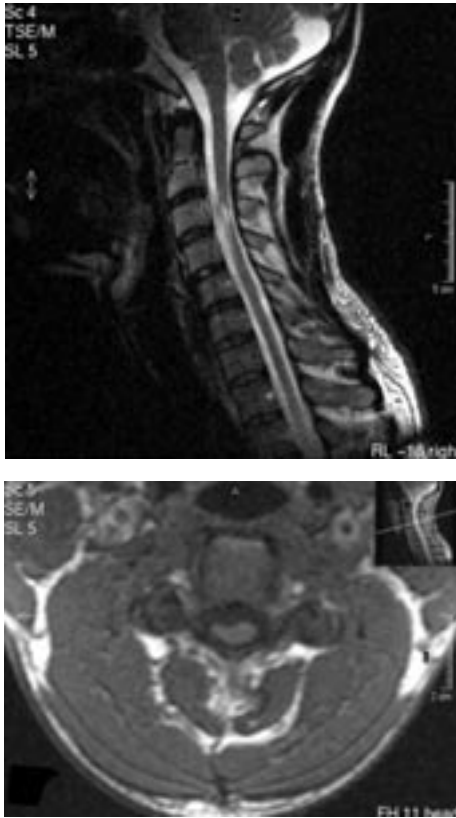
1.1 Sagittal T2-weighted MRI of the cervical spinal cord with atrophy and increased signal intensity of the cervical spinal cord (C3-C4). 1.2 Transverse T1-weighted MRI at the C3-level, showing atrophy of the spinal cord on the -clinically most affected- right side.
